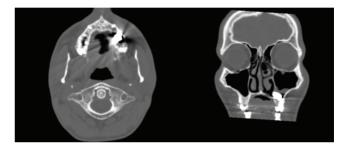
Axial and Coronal CT sections of the patient
